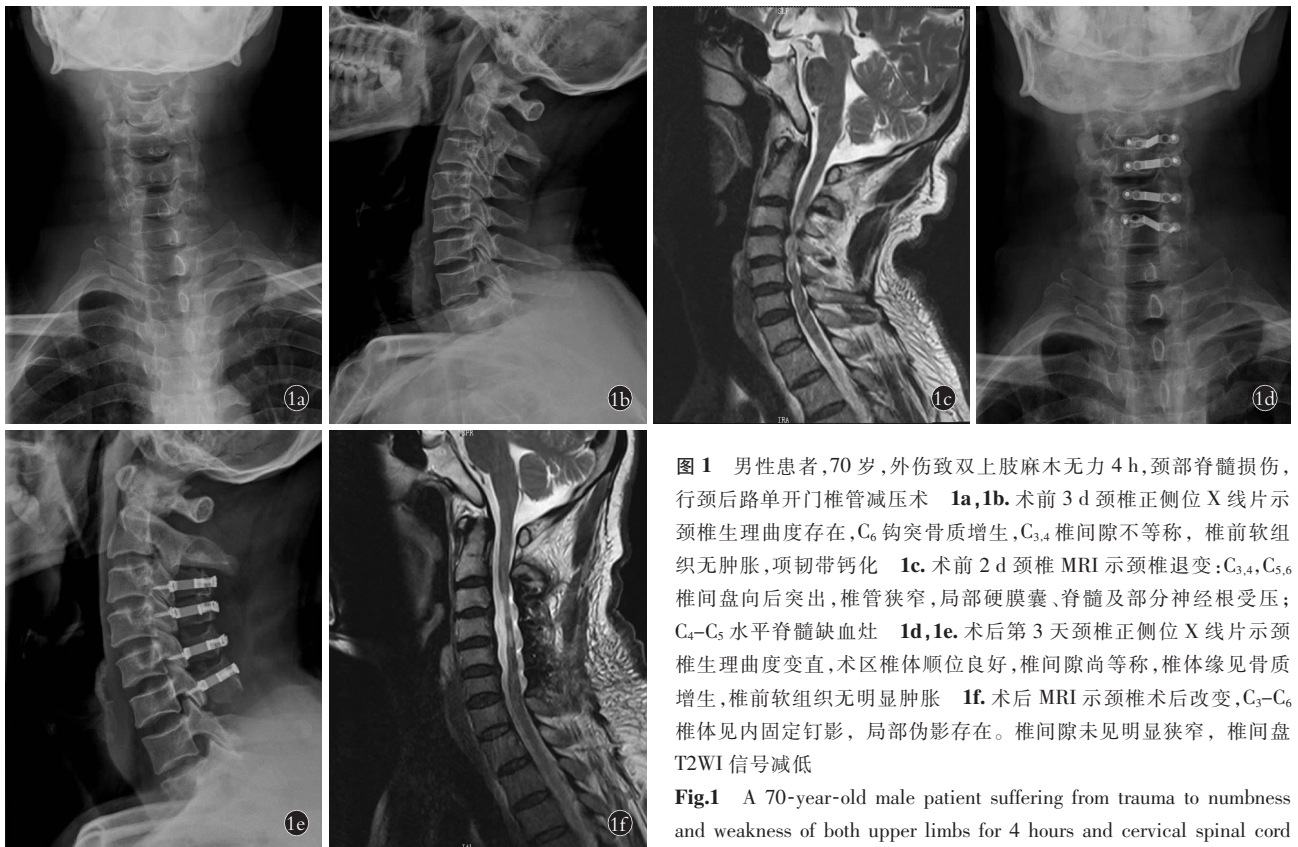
男性患者,70 岁,外伤致双上肢麻木无力 4 h,颈部脊髓损伤,行颈后路单开门椎管减压术 1a,1b。术前 3 d 颈椎正侧位 X 线片示颈椎生理曲度存在,C₆ 钩突骨质增生,C_{3,4} 椎间隙不等称,椎前软组织无肿胀,项韧带钙化 1c。术前 2 d 颈椎 MRI 示颈椎退变:C_{3,4},C_{5,6} 椎间盘向后突出,椎管狭窄,局部硬膜囊、脊髓及部分神经根受压;C₄-C₅ 水平脊髓缺血灶 1d,1e。术后第 3 天颈椎正侧位 X 线片示颈椎生理曲度变直,术区椎体顺位良好,椎间隙尚等称,椎体缘见骨质增生,椎前软组织无明显肿胀 1f。术后 MRI 示颈椎术后改变,C₃-C₆ 椎体见内固定钉影,局部伪影存在。椎间隙未见明显狭窄,椎间盘 T2WI 信号减低
